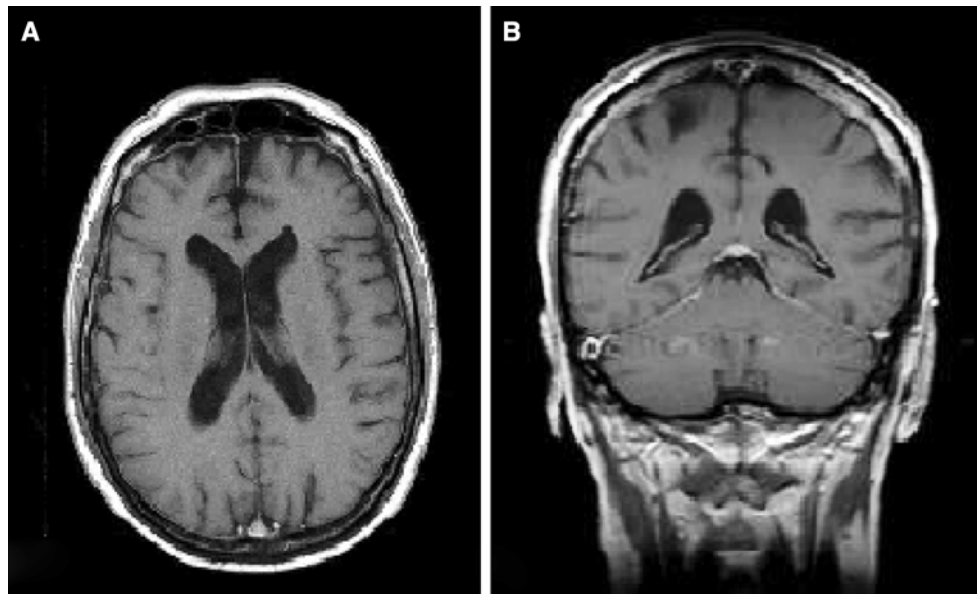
Axial (a) and coronal (b) T1-weighted contrast-enhanced MR images show markedly thickened and enhanced dura extending from the vertex to the tentorium
